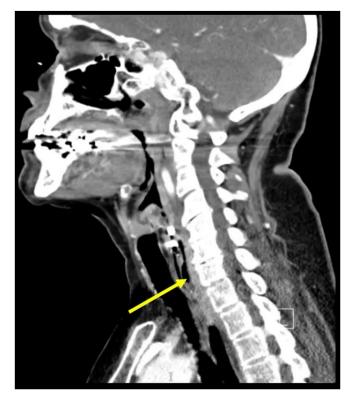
CT scan on postoperative day 10 with the yellow arrow demonstrating a persistent contained esophageal leak.
